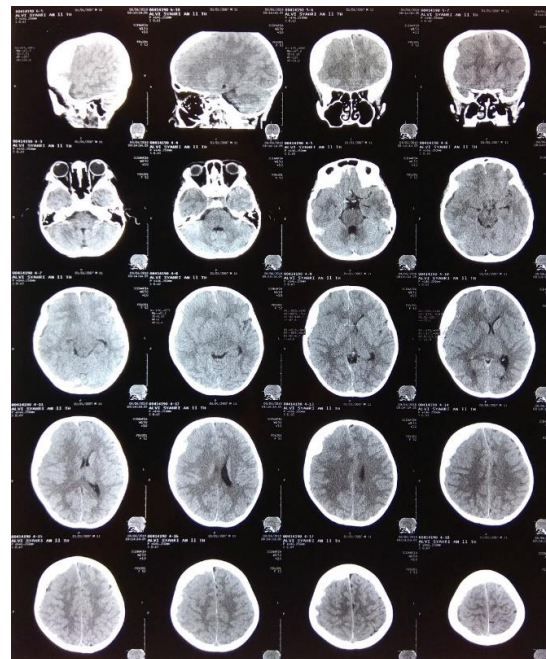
The CT Scan of Patient's Head Transverse View
